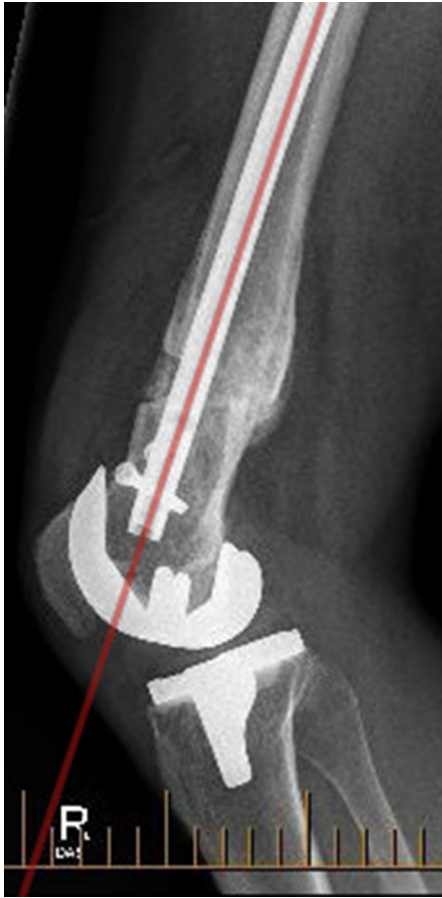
Lateral knee radiograph taken at 6 months postoperatively, with evidence of osteotomy union.
